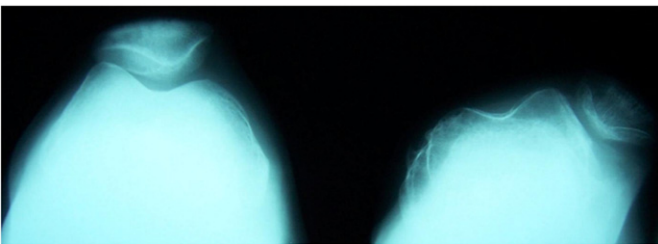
Preoperative Merchant view radiographs, three years following the knee injury.
